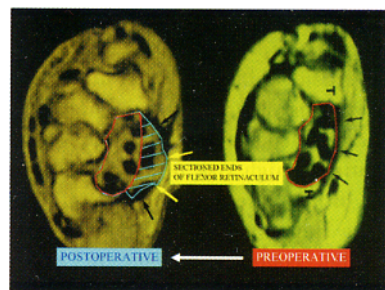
Pre and postoperative axial MRI of the carpal canal. Cross sectional area of the carpal canal is increased by release of the flexor retinaculum and DHFFR
